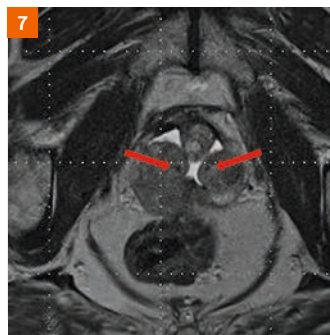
T2-weighted prostate 1.5T MRI from Gothenburg with Gold Anchor 0.40 mm x 20 mm.
